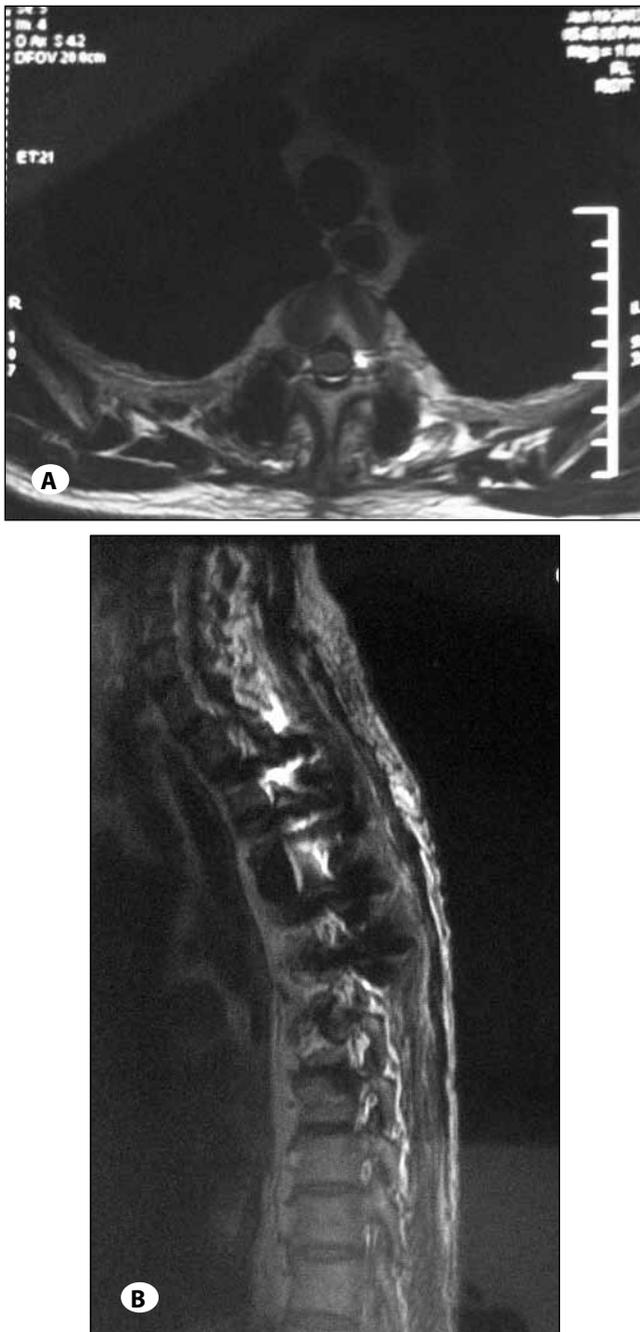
A) It showed there was no paravertebral recurrence of the glomus tumors in the transverse section of MRI. B) The inner fixation of the patient was maintained properly without loosening in the sagittal section of MRI.
